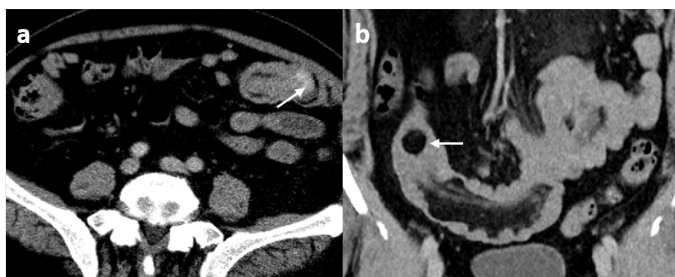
Axial contrast-enhanced CT image shows a jejunojejunal intussusception with a hyperdense intraluminal lesion (arrow), consistent with a hemangioma, serving as the leading point (a). Coronal contrast-enhanced CT image demonstrates a colocolic intussusception, with a lipoma identified as the lead point, associated with traction on adjacent mesenteric vessels (b).
